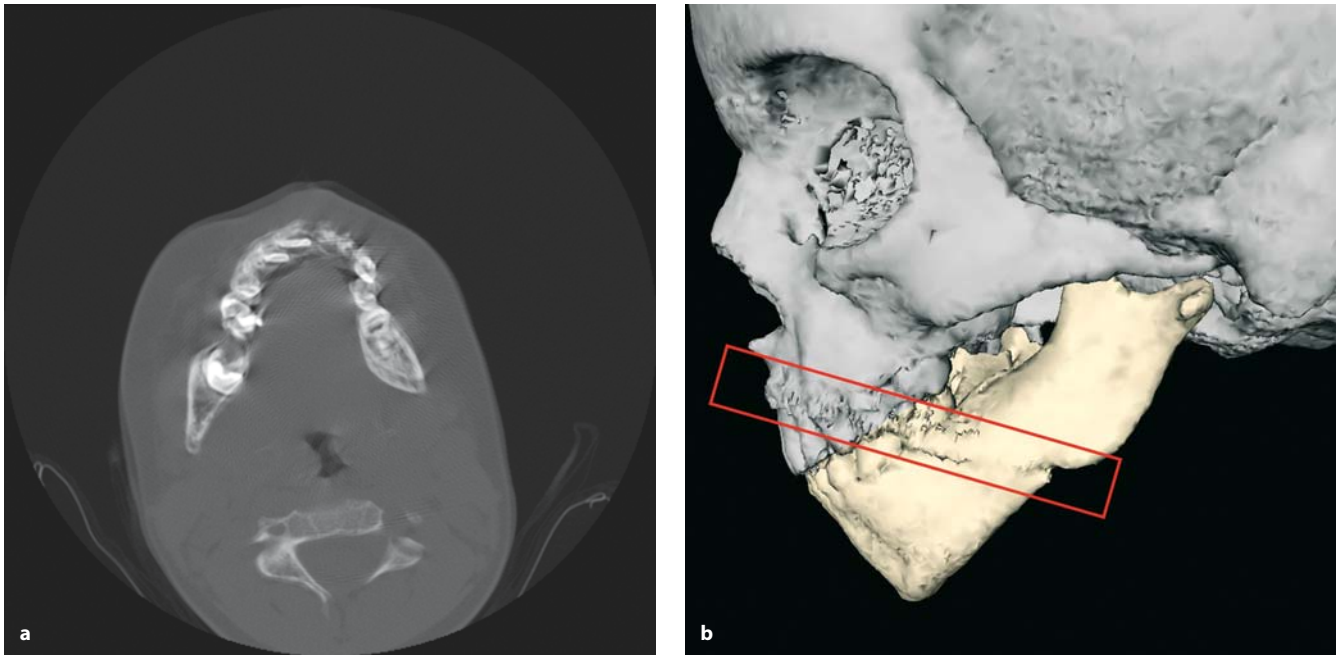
Movements of the patient during CT acquisition results in some blurred CT slices (a). As a consequence, the 3-D rendering of the bone is also distorted (b) at the position of the blurred CT slices
